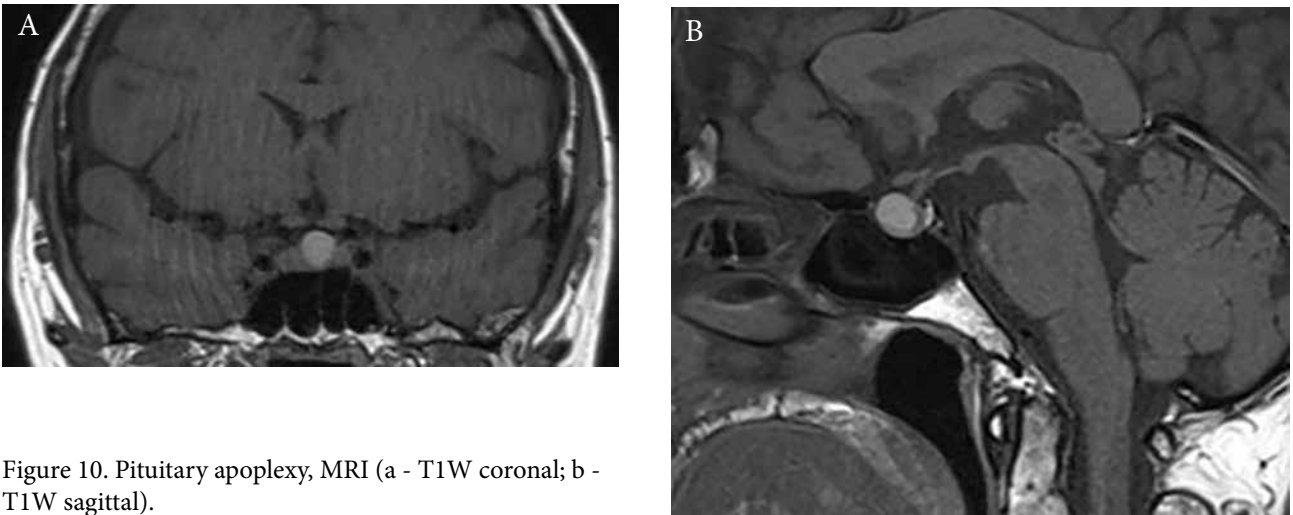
Pituitary apoplexy, MRI (a - T1W coronal; b - T1W sagittal).
